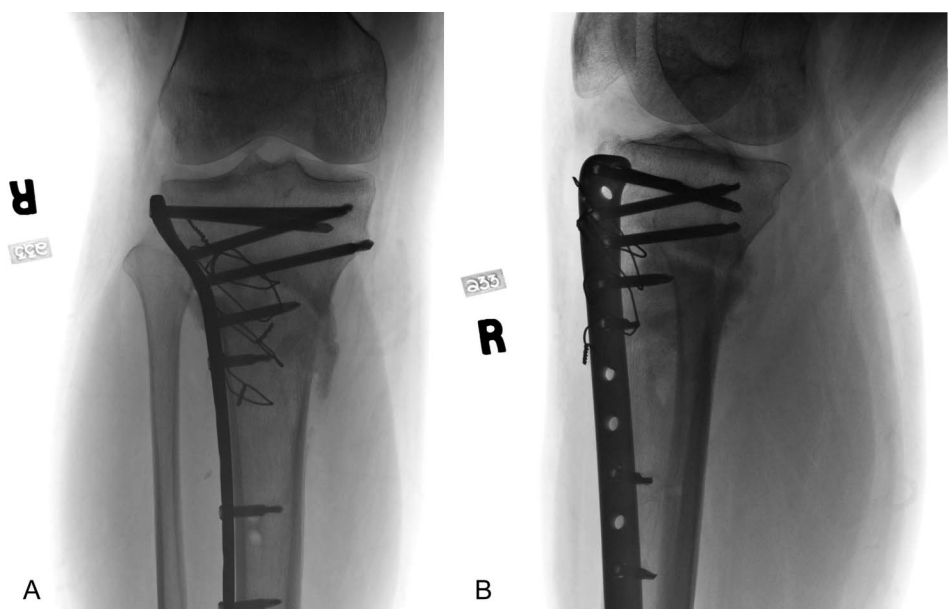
A, B, Anteroposterior and lateral radiographs of this same patient taken 5 months after fixation with an LISS plate and wiring of the tibial tubercle. Radiographic union is evident. LISS, less invasive stabilization system.
